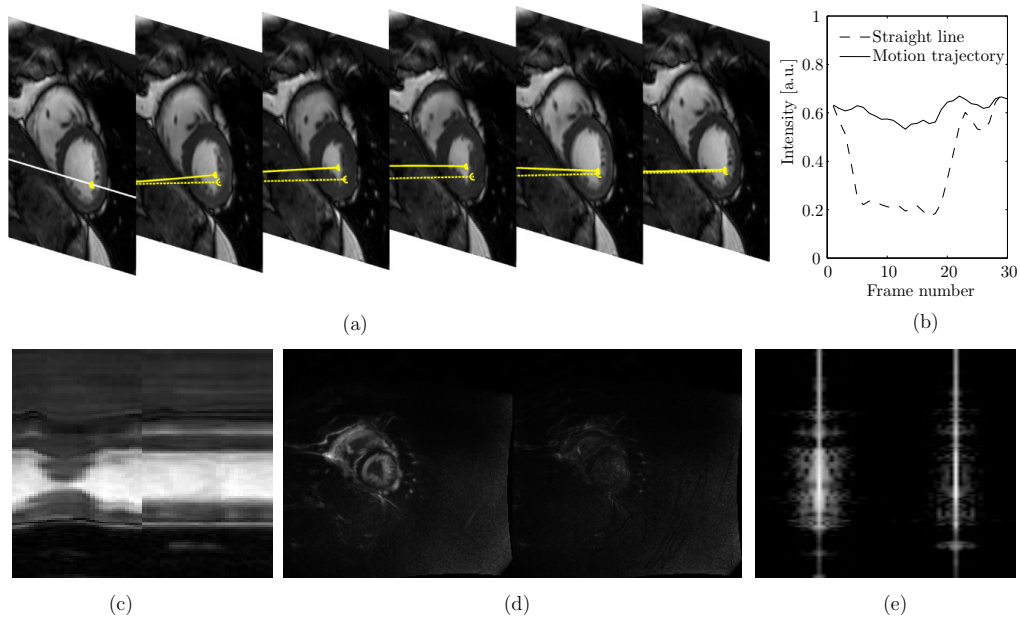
(a) Selected frames from a cine MRI sequence with estimated material point trajectory along time (continuous line) vs. fixed spatial position (dashed line). (b) Pixel intensity along time and along estimated motion trajectory. Lower and smoother intensity transitions are present in the second case. (c) Temporal evolution of a single slice in original sequence (left) and after compensate the estimated motion. Temporal total variation (TV) (d) and temporal log-Fourier transform (e) of the original and motion compensated sequences. In (d), a noticeable reduction in the TV values can be observed. In (e), the Fourier coefficients get more concentrated around the DC and low frequency components. The MC procedure contributes to obtain a sparser representation in the  $x$ - $f$  space.
